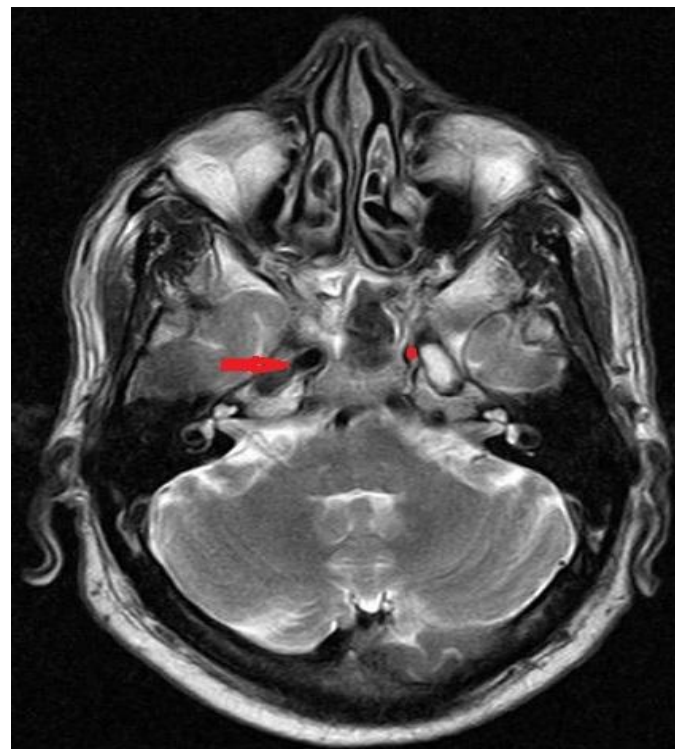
Axial MRI turbo spin-echo T2-weighted sequence showing absence of flow void in the left ICA (red dot), normal flow void in right ICA (red arrow).
